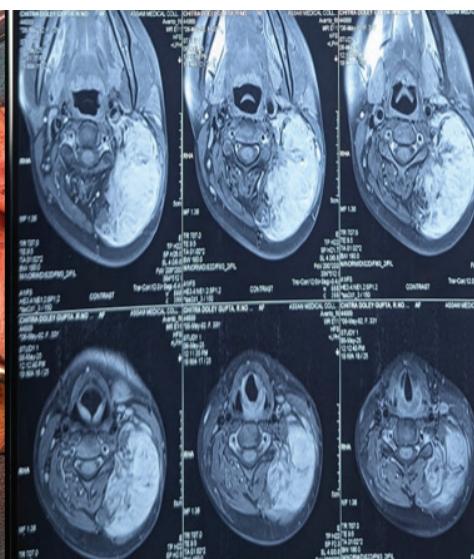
Contrast enhanced MRI neck
